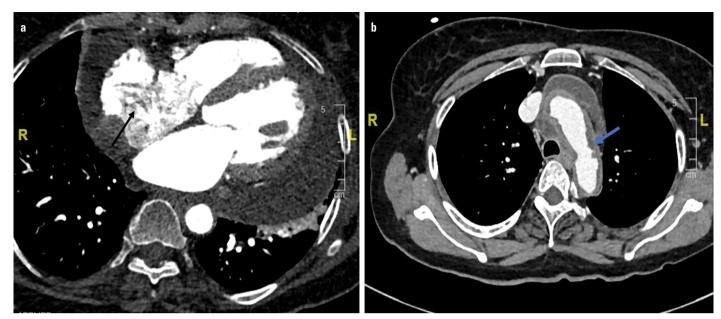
(a) Computed tomography angiogram showing hypertrophied crista terminalis, (b) Computed tomography angiogram showing the thickened arch of aorta with contrast enhancement
